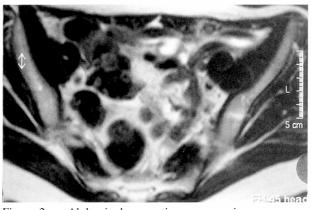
Abdominal magnetic resonance image scan revealing a heterogeneous lesion in the left rectus abdominis.
